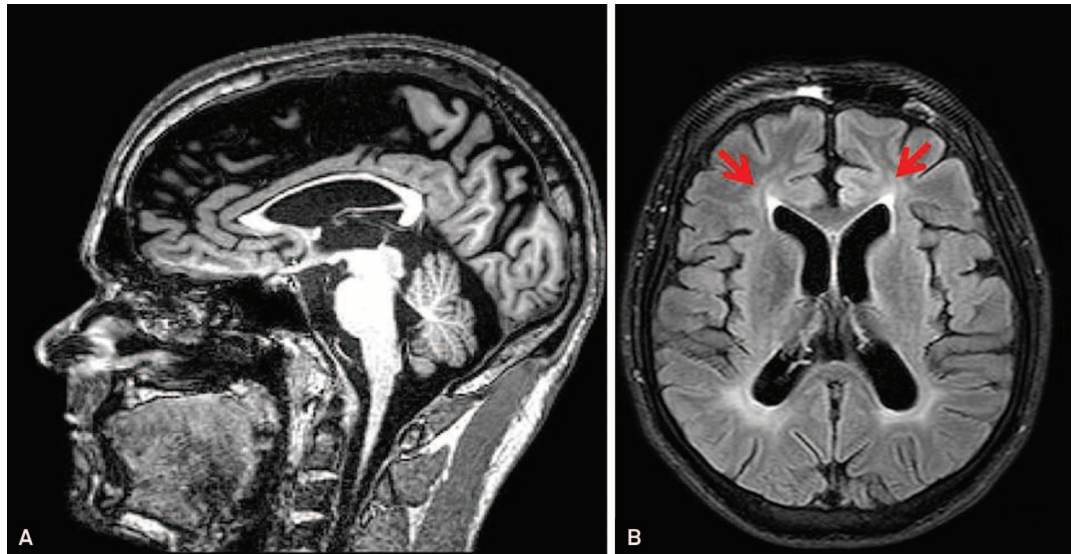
Magnetic resonance imaging of the brain of a patient with mutation in the *SPG11* gene (SPG11 phenotype): Sagittal T1 weighted imaging showing thinning of the Corpus Callosum (A). Axial FLAIR imaging showing the "ears of the lynx" sign (red arrows) (B).
